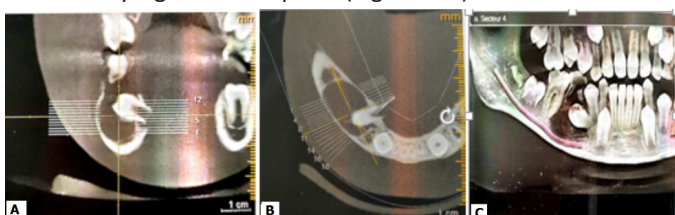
CBCT sagittal, coronal and panoramic sections.
